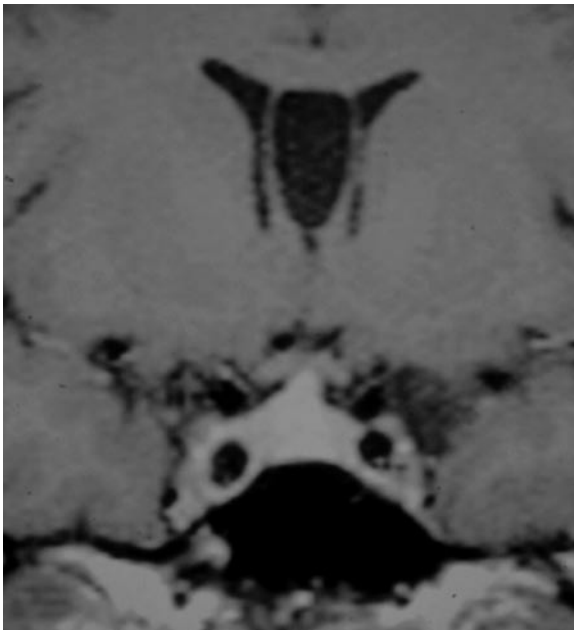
Lymphocytic hypophysitis. Coronal T1-weighted image after contrast administration. Enlargement of the pituitary gland and stalk
